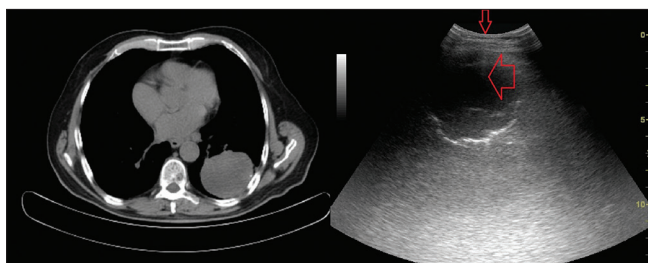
The ultrasonographic image of a 5 cm × 5 cm mass in the lower lobe of the left lung on thorax computed tomography. The entrance localization, and the distance of the needle in the mass were indicated in red color
